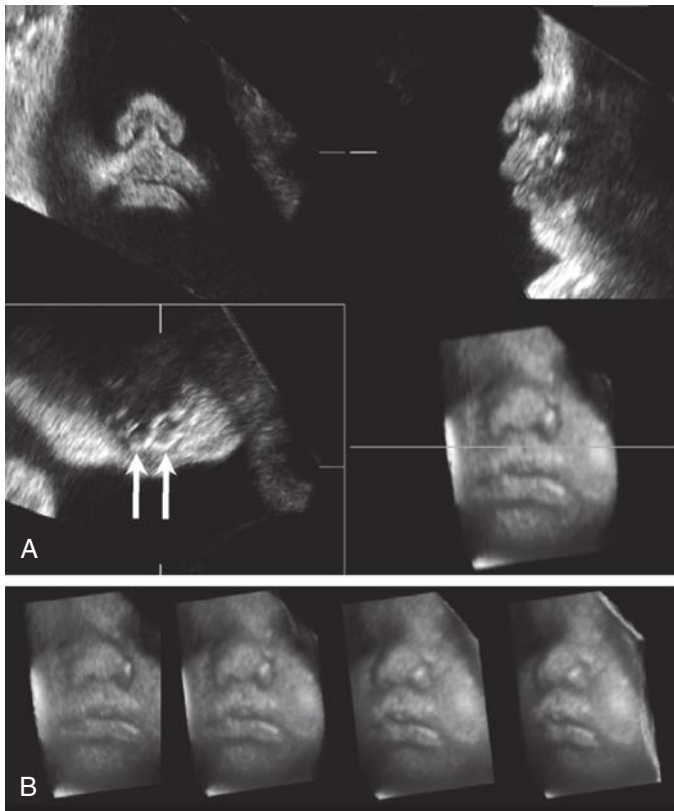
Normal fetal face at 35 menstrual weeks. A, Multiplanar and volume-rendered images of the fetal face are displayed. *Upper left*, a coronal view through the nose and lips is seen. *Upper right*, a sagittal or profile view of the face is seen. *Lower left*, an axial plane through the anterior alveolar ridge of the primary palate is shown. *Lower right*, a volume-rendered image of the face using surface and light techniques is shown. A line is visible crossing the upper lip of the fetus, which identifies the level of the axial plane in the lower left box. Note two tooth buds in the anterior alveolar ridge (*arrows*). B, Images from multiple rotations of the fetal face are shown. Generally, a volume is rotated with a knob on the work panel to provide the impression of three-dimensionality. (From Pretorius DH, Nelson TR: Three-dimensional ultrasound in gynecology and obstetrics. *Ultrasound Q* 14:218-233, 1998.)
